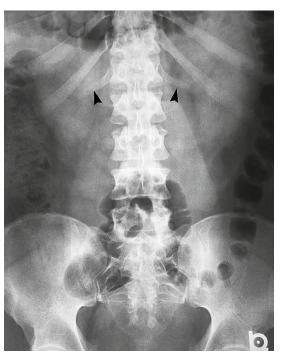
Anteroposterior lumbar spine radiograph demonstrating bilateral lumbar ribs (arrowheads). (From Riverside Methodist Hospital, Columbus, Ohio.)
